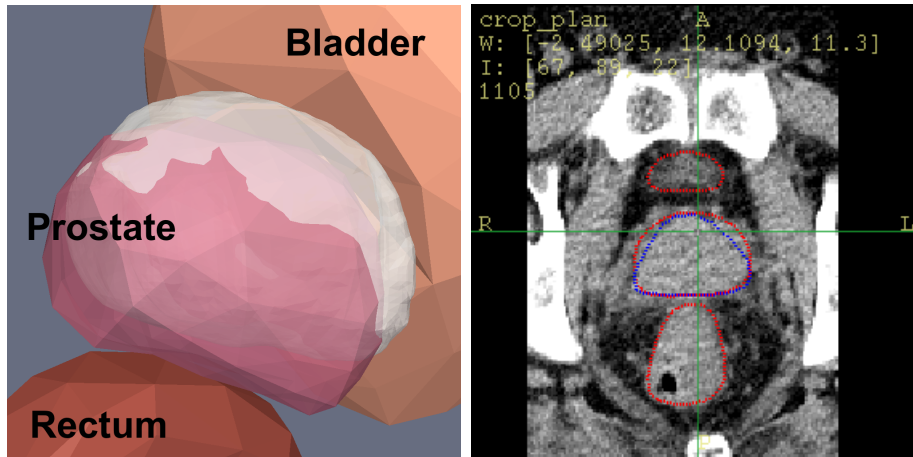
A typical scene of the male pelvis region: the movement of the bladder and rectum deforms the prostate. Left: a 3D rendering of the organ surfaces; the white surface represents the target surface of the prostate. Right: a slice of a CT image of the area; the red contour shows the segmentations of the reference image, and the blue contour shows the prostate in the target image.
